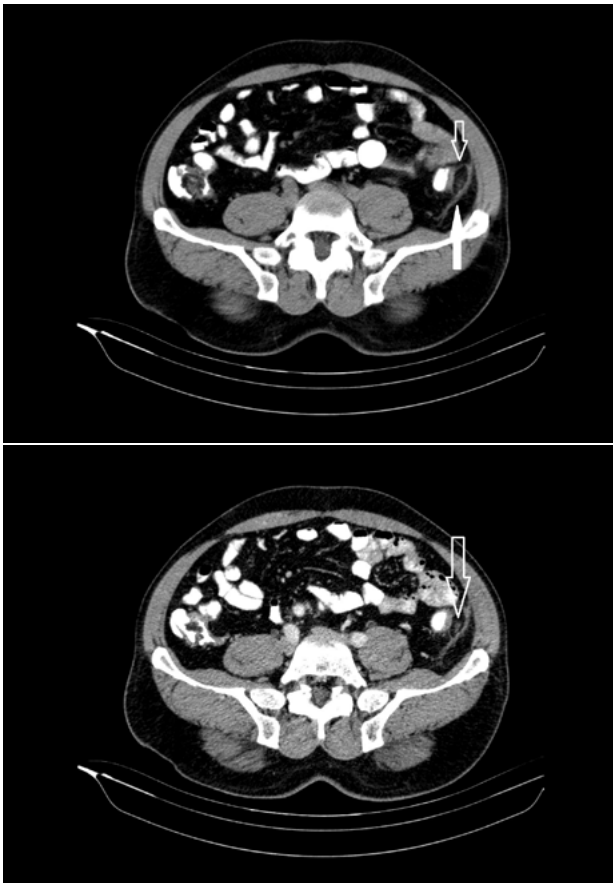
(A-B): The axial contrast-enhanced CT images show an oval fat lesion characterized by a hyperattenuated peripheral border (A), and an associated localized thickening of the peritoneum (A, white arrow). Additionally, the CT images depict severe fat stranding, along with a fatty ovoid mass featuring a hyperattenuated rim and a central dot (B).
